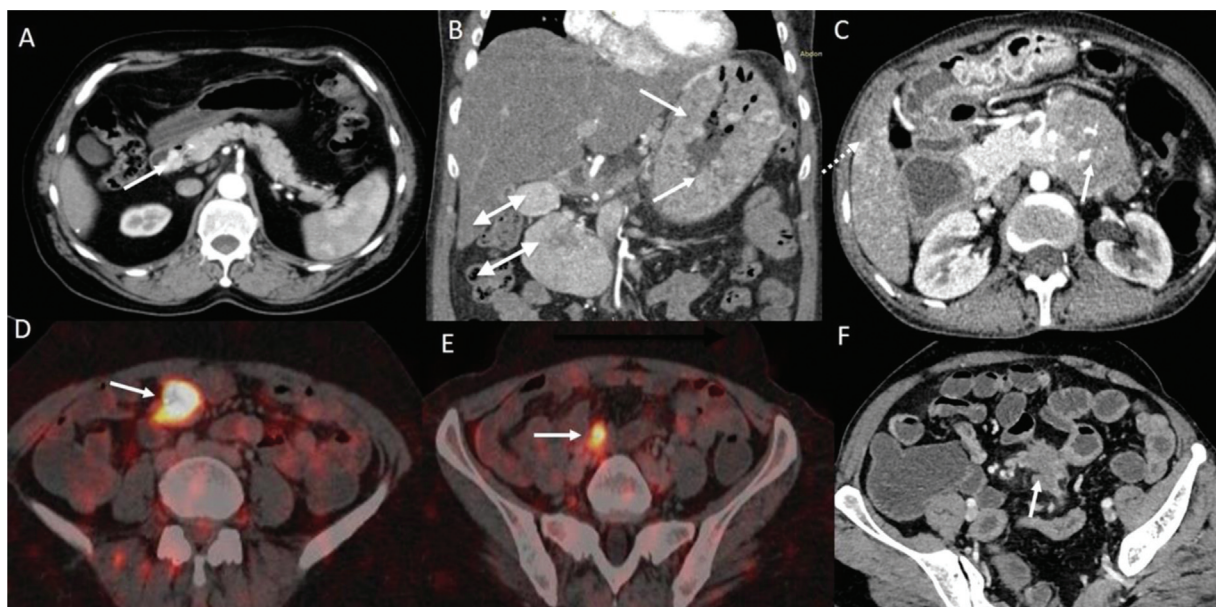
Neuroendocrine tumor: (A) Solitary hypervascular lesion within the duodenal lumen (arrow); (B) Coronal image showing multiple neuroendocrine tumors (NETs) in the stomach (white arrows) and hypervascular lymph nodes (double headed white arrows), (C) Hypervascular NET in the duodenum with calcifications (arrow) with liver metastasis (dashed arrow); (D, E): Somatostatin analogue positron emission tomography images showing avid lesions in the mesentery (arrow); (F) Computed tomography enterography image showing spiculated hypoenhancing mesenteric mass lesion (arrow).
